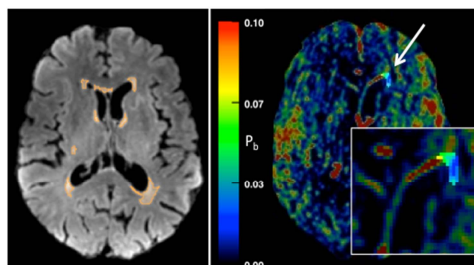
(Left) FLAIR image from a 74 year old male shows good suppression of the cerebrospinal fluid. Both periventricular and more focal, deep lesions are identified (orange). In-plane area of WMHs ranged from 17-147 mm². (Right) p_b map with magnification of the periventricular WMH indicated by arrow (inset).
